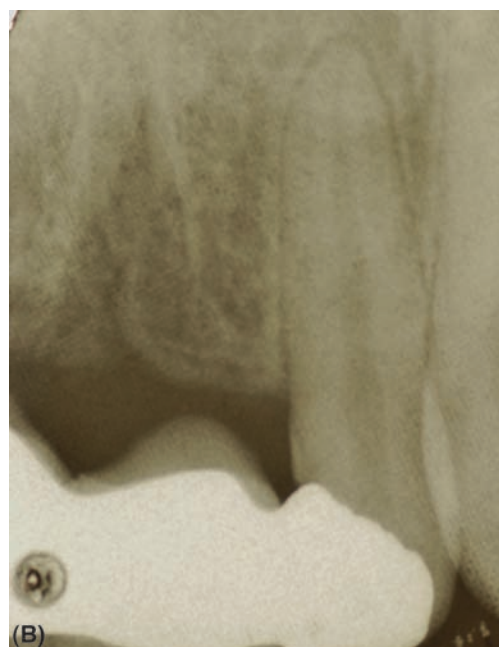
A series of photographs showing nerve removal and canal obliteration of the maxillary incisive canal. (A, B) Preoperative views showing the large incisive papilla and the large radiolucency on the intraoral radiograph. Insufficient space is available to predictably place implants into the central incisor sites. (C) Buccal and palatal mucoperiosteal flaps have been raised to expose the incisive canal and nerve that is held under tension. (D) The nerve is removed with hand instruments and the canal is curetted to its full depth to remove any residual soft tissue remnants. (E) Bone chips harvested from the retromolar area with a Safescraper[®] TWIST are placed into the void and compacted (E, F). (G) Soft tissue closure is achieved without the use of a membrane as the graft is within the bony contour and is protected by the overlying periosteum. Note that the crestal incision has been placed toward the buccal aspect of the crest to keep it remote from the graft site. (H) Postoperative radiograph to show increased density of bone in the incisive canal region.
